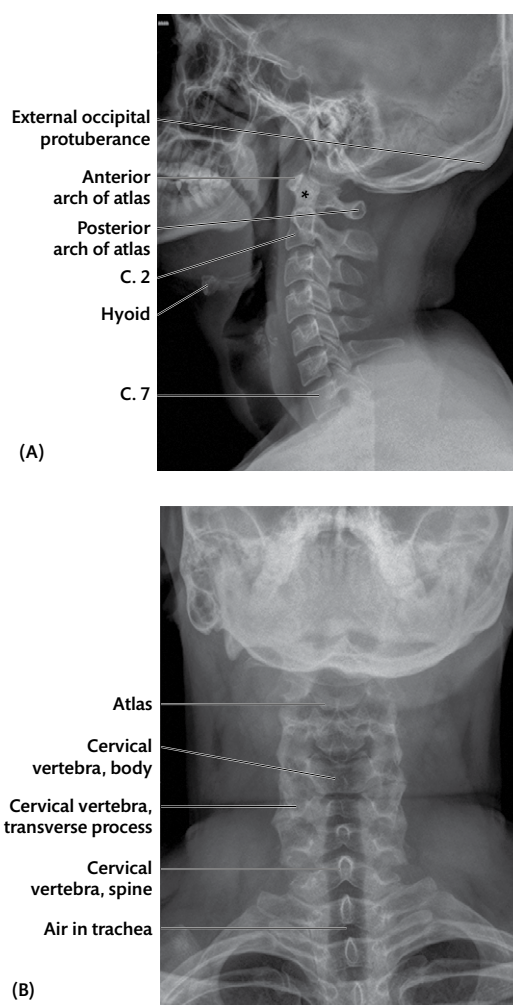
(A) Lateral radiograph and (B) anteroposterior (AP) view of the neck. C. 2, C. 7 = second and seventh cervical vertebrae, respectively. * = dens.
